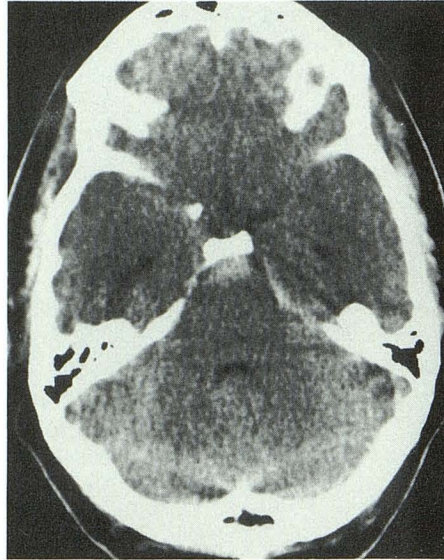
CT scan shows isolated clot in prepontine cistern.
